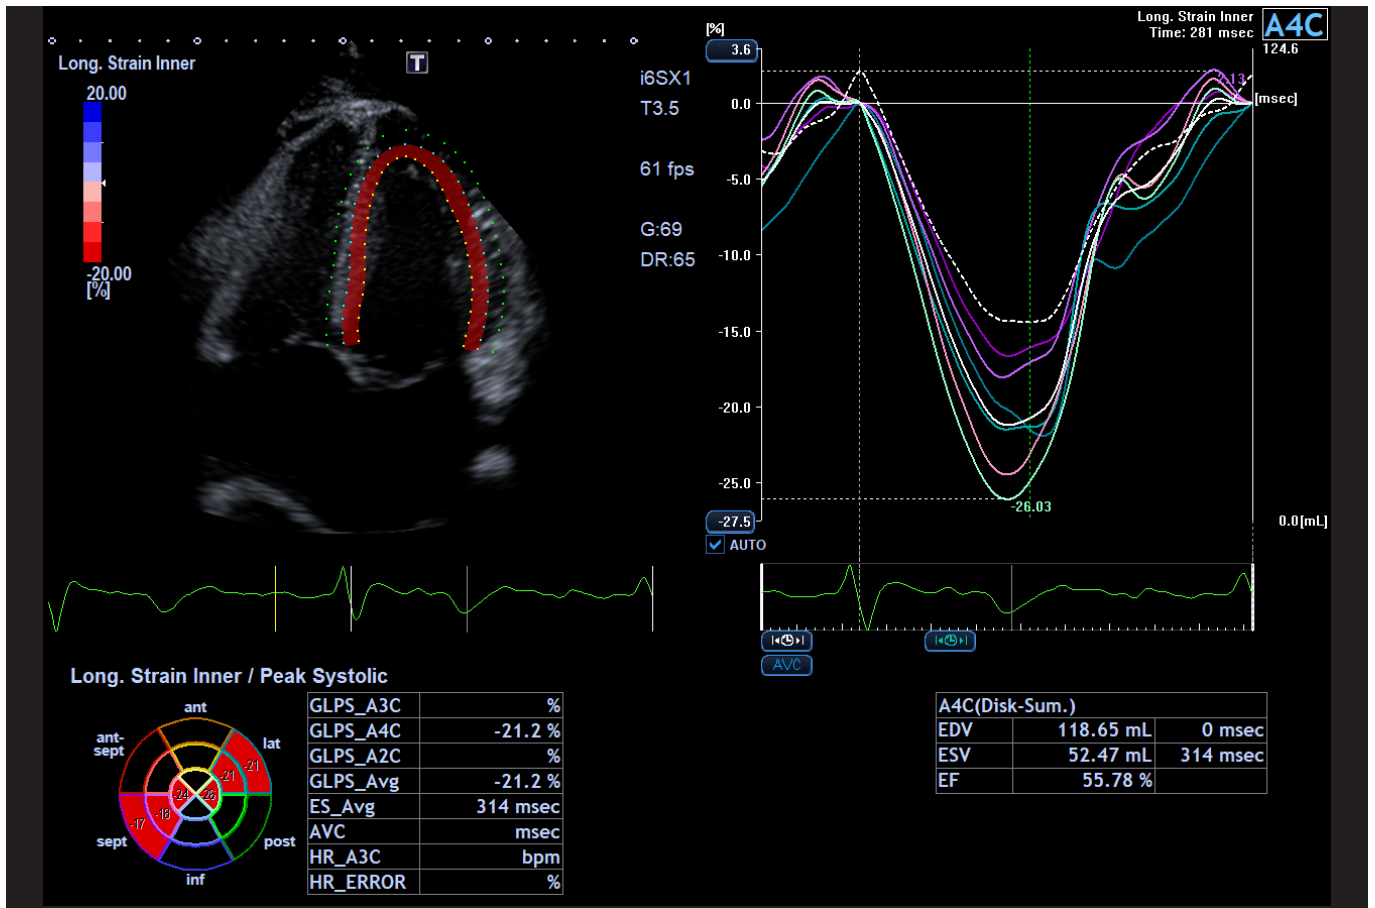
Resting LV longitudinal strain analysis of the apical four chamber view using Canon Vitrea for ultrasound (V7.11) software.
